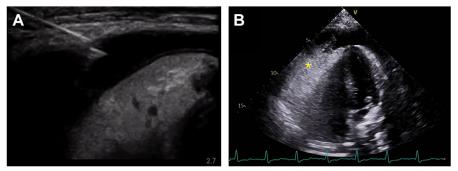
Ultrasound (US)-guided pericardiocentesis. (*A*) In-plane using a linear probe, visualizing needle tip entering the pericardial fluid collection. (*B*) Agitated saline (asterisk) is seen in the pericardial space on apical 4-chamber view. (*Photo Courtesy* of Stephen Alerhand, MD.)
